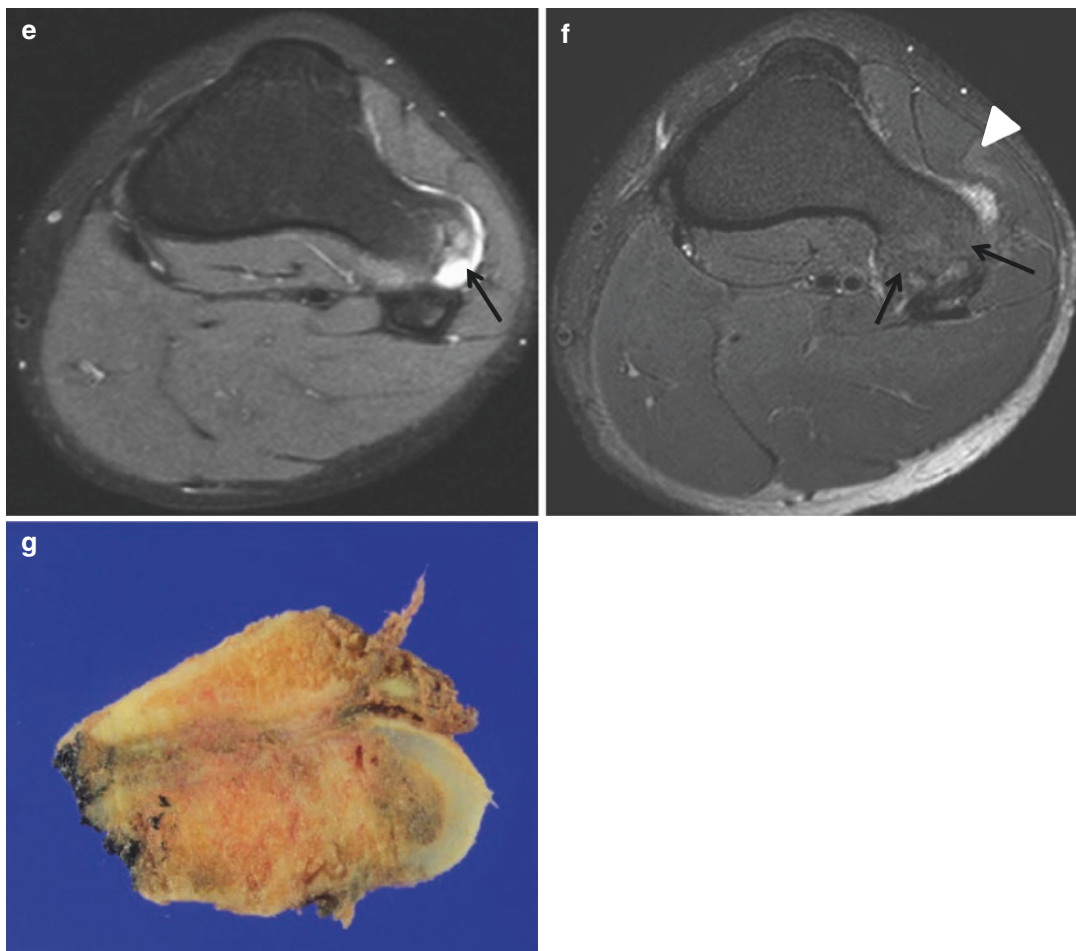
Osteochondroma. (a) Sagittal T2-weighted MR image shows a surface lesion composed of lamellar bone (*arrow*) covered by a cartilage cap (*arrowhead*). (b) Sagittal fat-suppressed T2-weighted MR image demonstrates a surface lesion composed of lamellar bone (*arrow*) covered by
